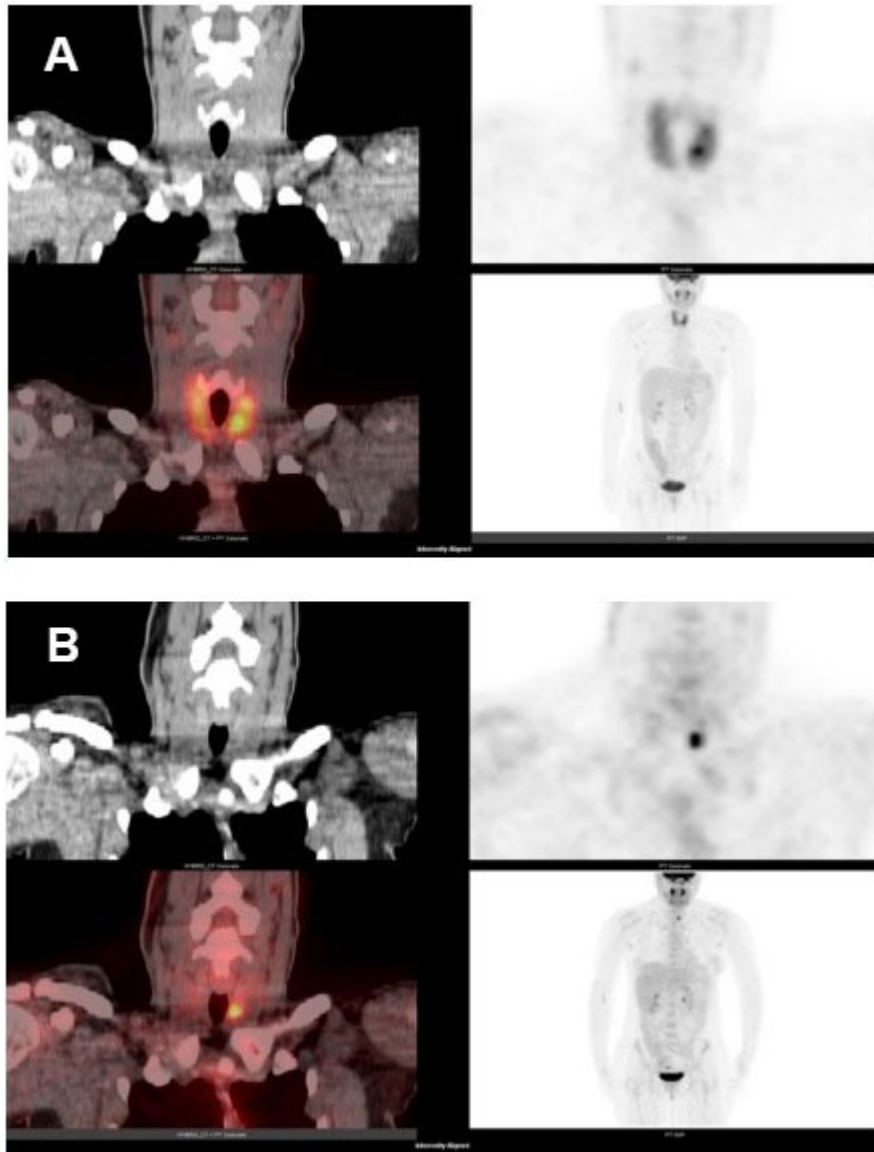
This is a case of diffuse-plus-focal FDG uptake transitioned to focal uptake in a patient with Stage III melanoma. (A) Diffuse-plus-focal FDG uptake (diffuse SUV 8.4, focal SUV 12.8) in the thyroid during treatment with interferon therapy resulting in induced primary hypothyroidism treated with l-T4. (B) FDG uptake regressed after treatment of thyroiditis to a focal area of increased uptake in the left thyroid lobe, SUV 9.8. Final pathology after total thyroidectomy showed multifocal papillary thyroid carcinoma.
